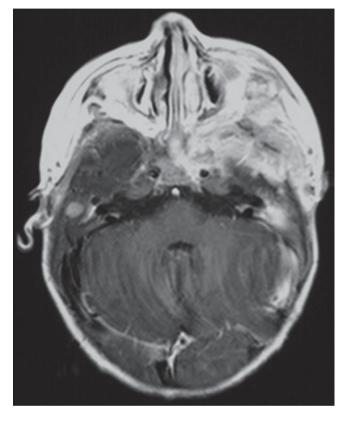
MRI performed at the time of diagnosis in a child with severe involvement of the skull base with intracranial extension
